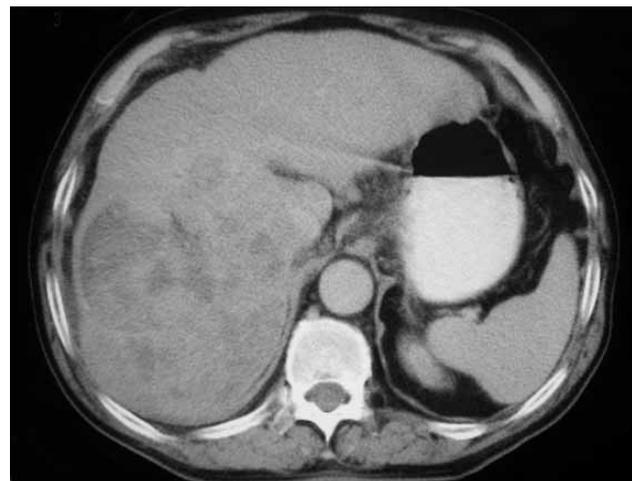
Abdominal computed tomography showed the complete involvement of posterior segment of the right hepatic lobe.
